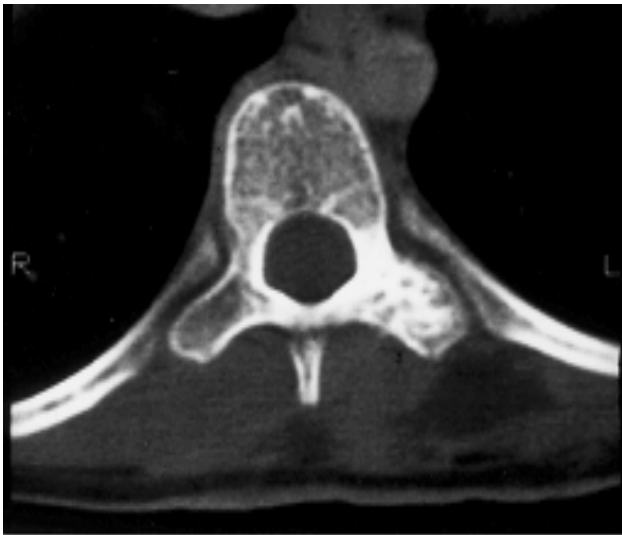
CT scan at the level of T9: The destruction of the head and neck of the left 8th rib and abnormal trabecular pattern in the transverse process of T9.
